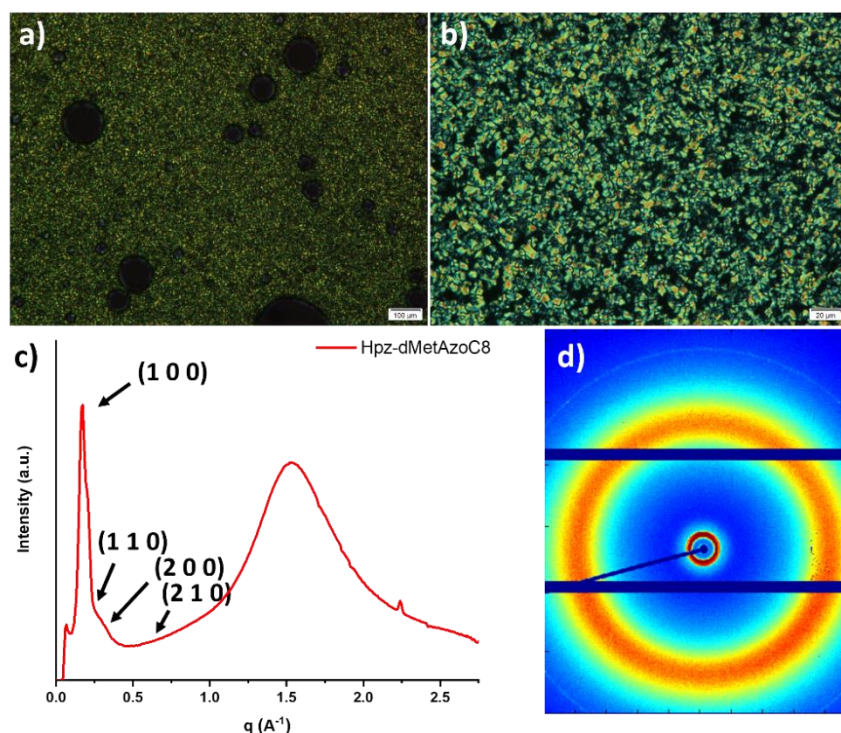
a-b) POM microphotograph of Hpz-dMetAzoC₈ at r.t. during the cooling cycle. c-d) 1D and 2D X-ray patterns of Hpz-dMetAzoC₈.
